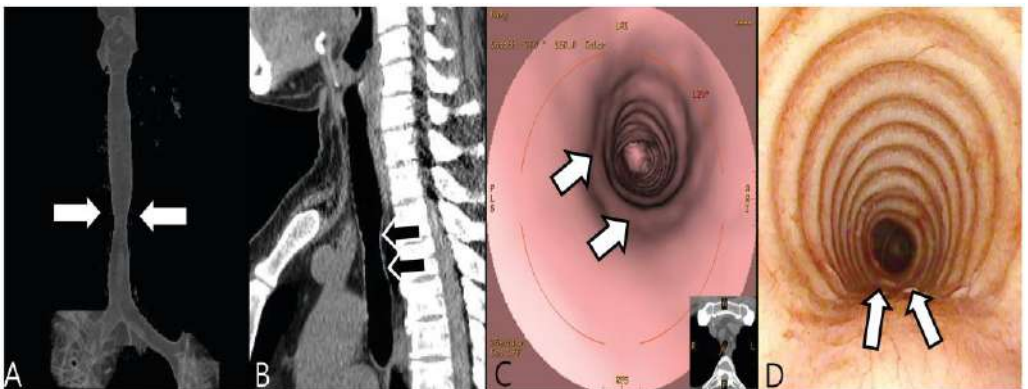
Virtual chest CT and bronchoscopic images
